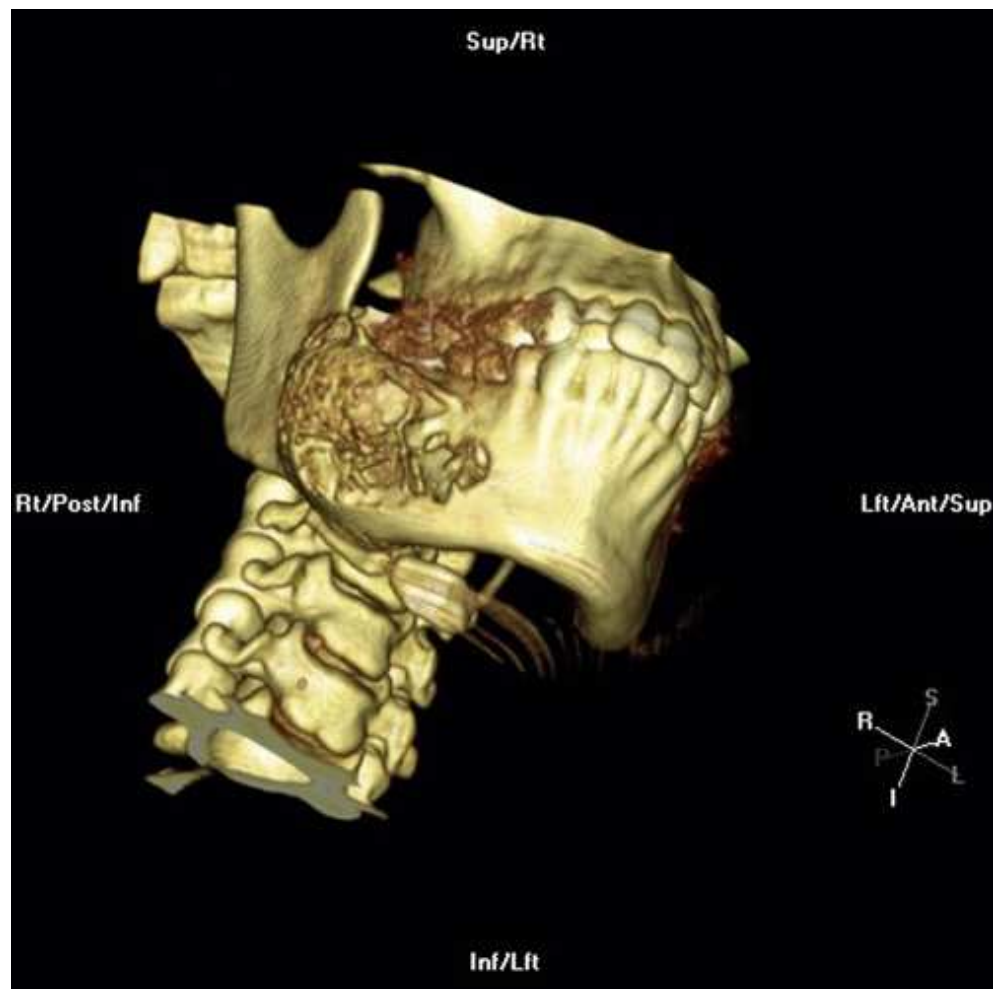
CT shaded surface display (SSD) with anterior lighting effects. From Weber State University, School of Radiologic Sciences.
